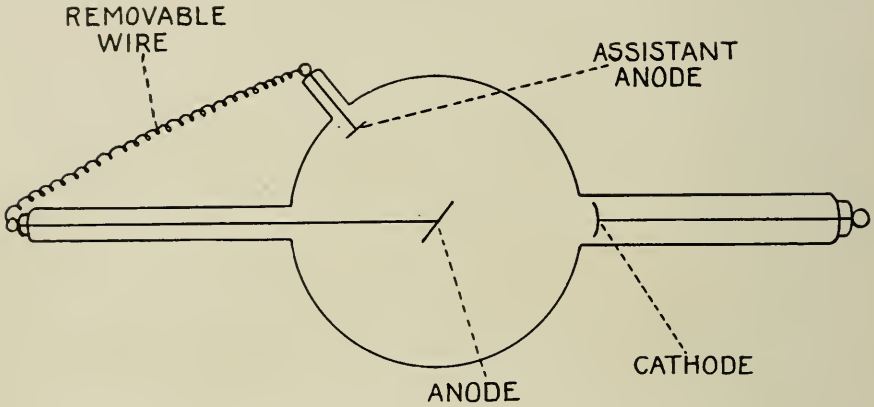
A Bi-Anodal X-ray tube.
